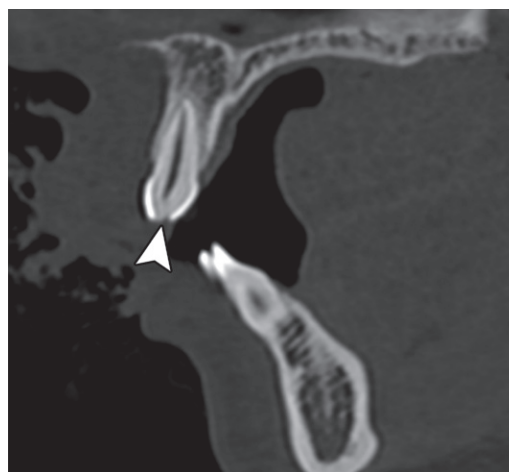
Dental crown fracture. Sagittal CT image (bone window) shows a fracture of enamel and dentin without pulp involvement (arrowhead).
